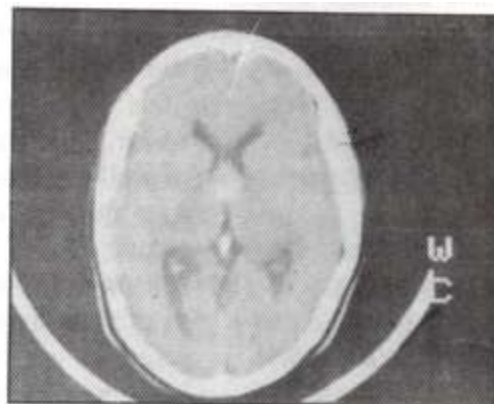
Axial contrast enhanced CT scan showing colloid cyst at the level of Foramen of Monro with hydrocephalus
